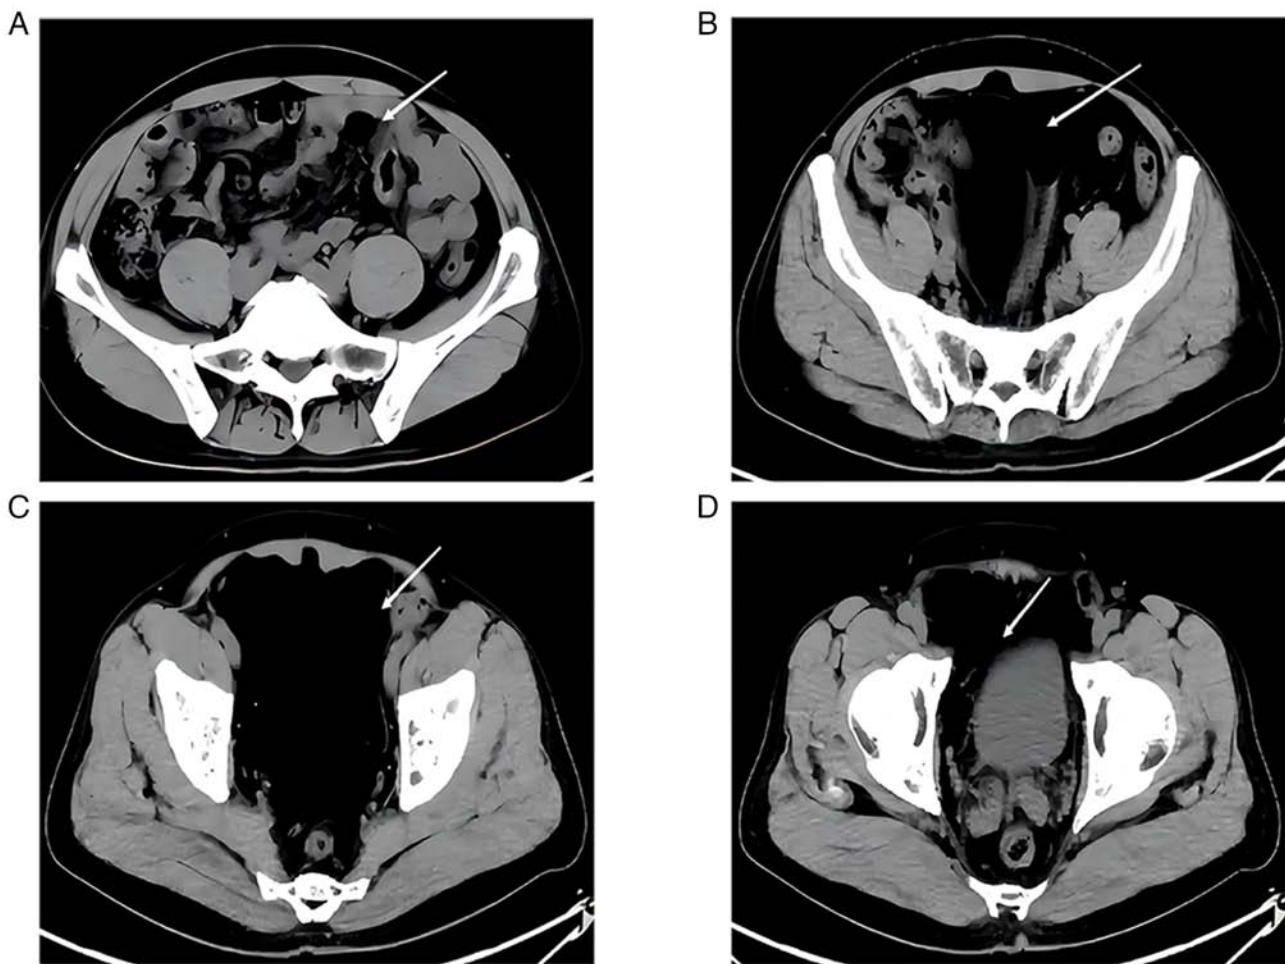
CT scan images of the tumor (October 2022). Lipoma (A) at presentation (white arrow indicates the presence of the lipoma) and (B) after a gradual increase in size (the arrow indicates that the lipoma is significantly enlarged and compressing the surrounding tissue). (C) Largest cross-section of the lipoma (the arrow indicates at the maximum transverse diameter of the lipoma, adjacent to the surrounding tissue.). (D) Association between the lipoma and bladder (the arrow indicates where the lipoma is adjacent to the bladder).
